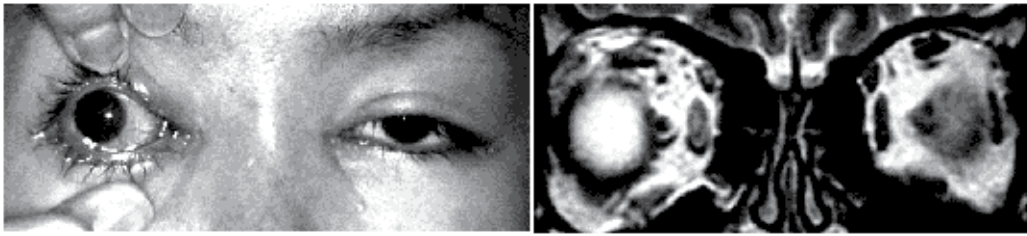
Orbital inflammation associated with a foreign body. Left: A 29-year-old woman underwent cosmetic rhinoplastic surgery by a cosmetic surgeon. She developed ocular pain and a decrease of vision after the PMMA was injected. The right eye was displaced temporally leading to blepharoptosis. Her ocular motility was restricted. Right; T2-weighted MRI shows high signals from the right rectus muscles especially the medial rectus muscle. Reproduced with permission from Kubota T & Hirose H. (2005) Permanent loss of vision following cosmetic rhinoplastic surgery. *Japanese Journal of Ophthalmology*, Vol.49, No,6, pp.535-6, ISSN:0021-5155
